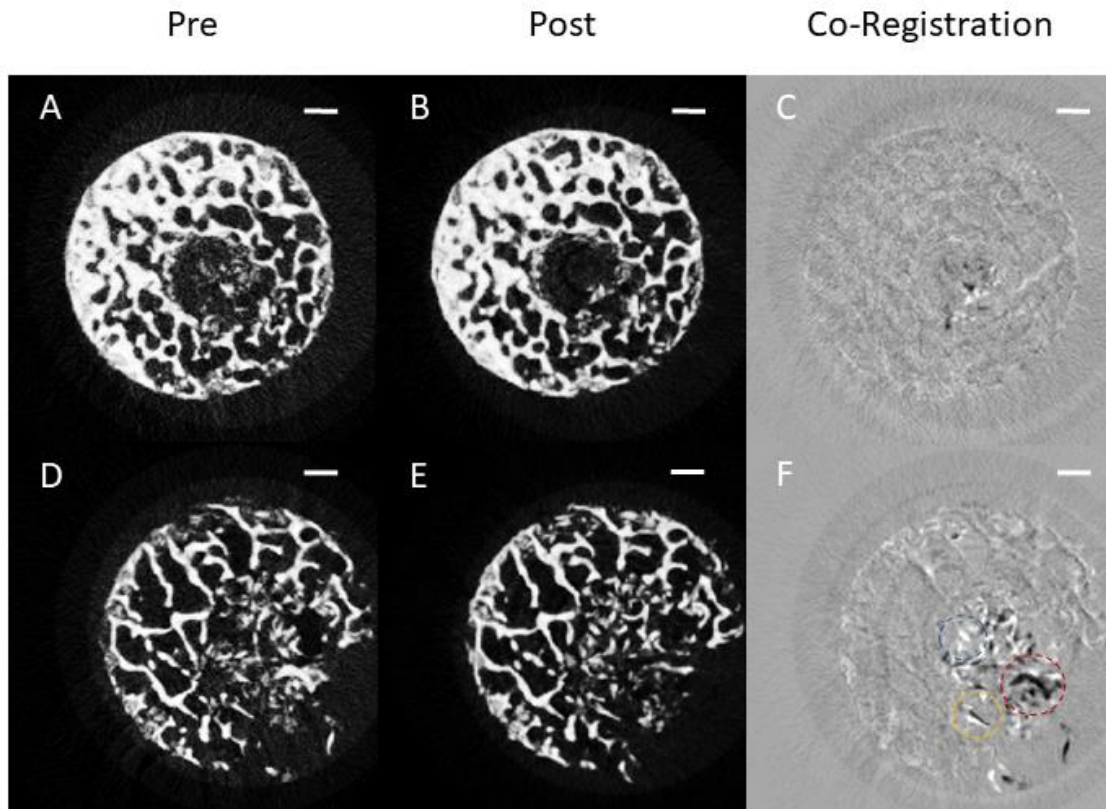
Reconstructed μ CT images of a bone core at two different planes. (A) and (D) are representative images taken before CAM incubation, (B) and (E) are images of the same core taken after a 10 day CAM incubation. (C) and (F) are the pre and post images overlaid showing areas of bone misalignment (yellow), bone loss (red) and bone gain (blue). All following μ CT analysis was produced using this reconstruction method. Scale bar= 1 mm.
